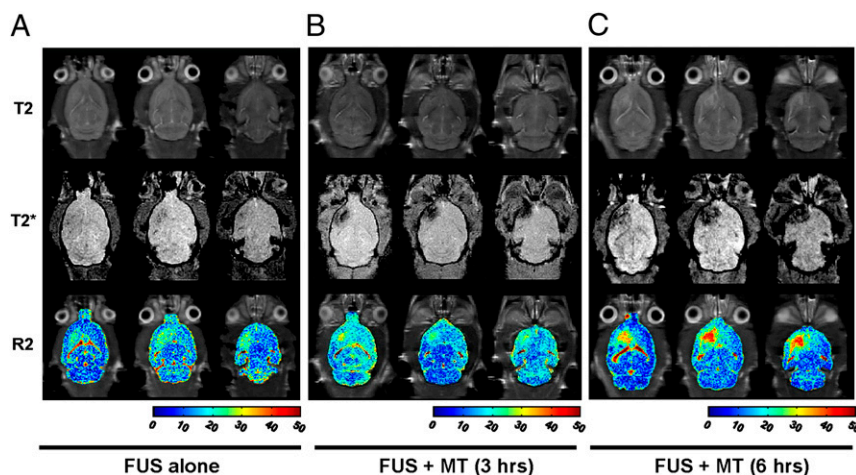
In vivo imaging of MNP distribution in the brain (Top, T2-weighted images; Middle, T2*-weighted images; Bottom, combined R2 maps and T2-weighted images). (A) FUS sonication and MNP injection. (B) FUS followed by MT for 3 h after MNP injection. (C) FUS followed by MT for 6 h after MNP injection.
